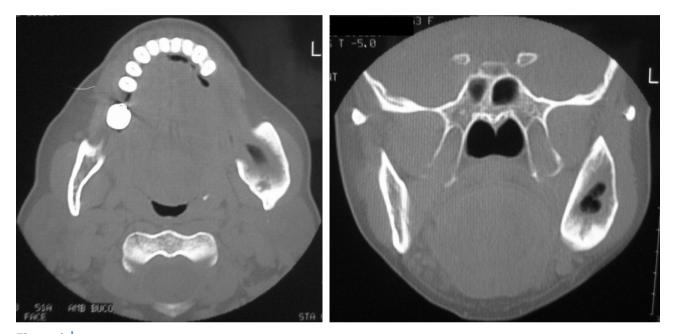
A, B: Bone CT scans showing the unilocular aspect of the tumour associated with lateral bulge and the absence of cortical fenestration. Note the heterogeneous pattern of the lesion and areas with hypodense aspect.
